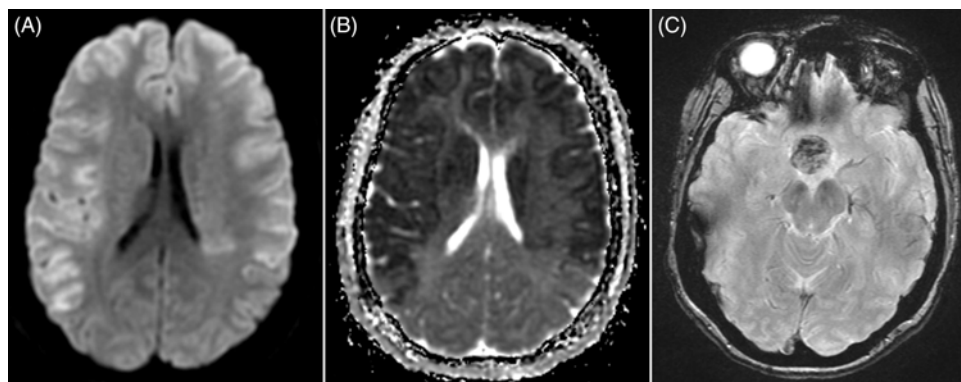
Cerebral magnetic resonance imaging in a patient with pituitary apoplexy. Hyperintense signal on diffusion weighted imaging (A) and hypointense signal on apparent diffusion coefficient (B) demonstrating complete bilateral internal carotid artery infarction. Gradient recovery echo (C) showing hemosiderin deposits in the pituitary gland consistent with pituitary apoplexy.
